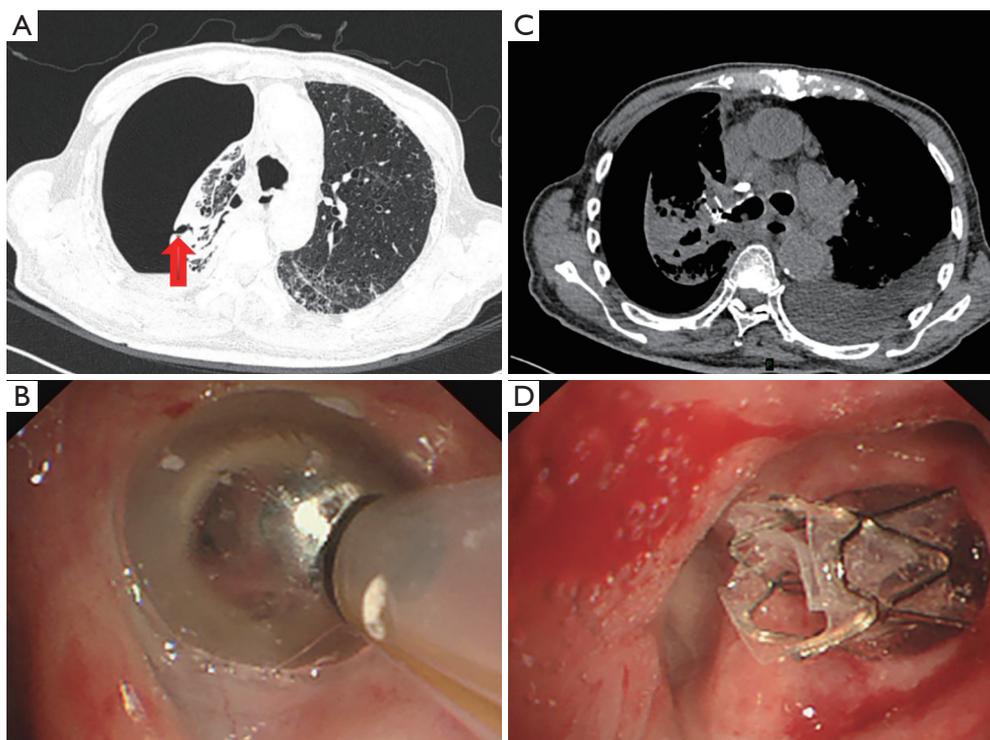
The chest CT scan and bronchoscopic view of BPF related to *M. chelonae* in the case one. The pulmonary window of the initial CT scan showing bilateral pneumonia pattern and right-side hydro-pneumothorax. The red arrow indicates a fistula in the right upper lobe (A). The bronchoscopic view of the Chartis balloon catheter (B). The mediastinal window of the CT scan showing EBVs in the right B2b and B3b segments one week after valve insertion (C). The bronchoscopic view of the EBV in the right B2b (D). CT, computed tomography; BPF, bronchopleural fistula; EBV, endobronchial valve.
